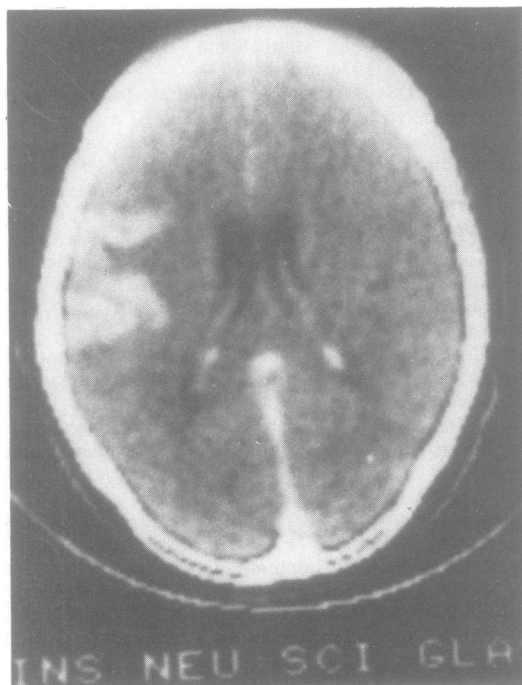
Fig CT scan with contrast enhancement showing large lesion in left fronto-parietal region.
